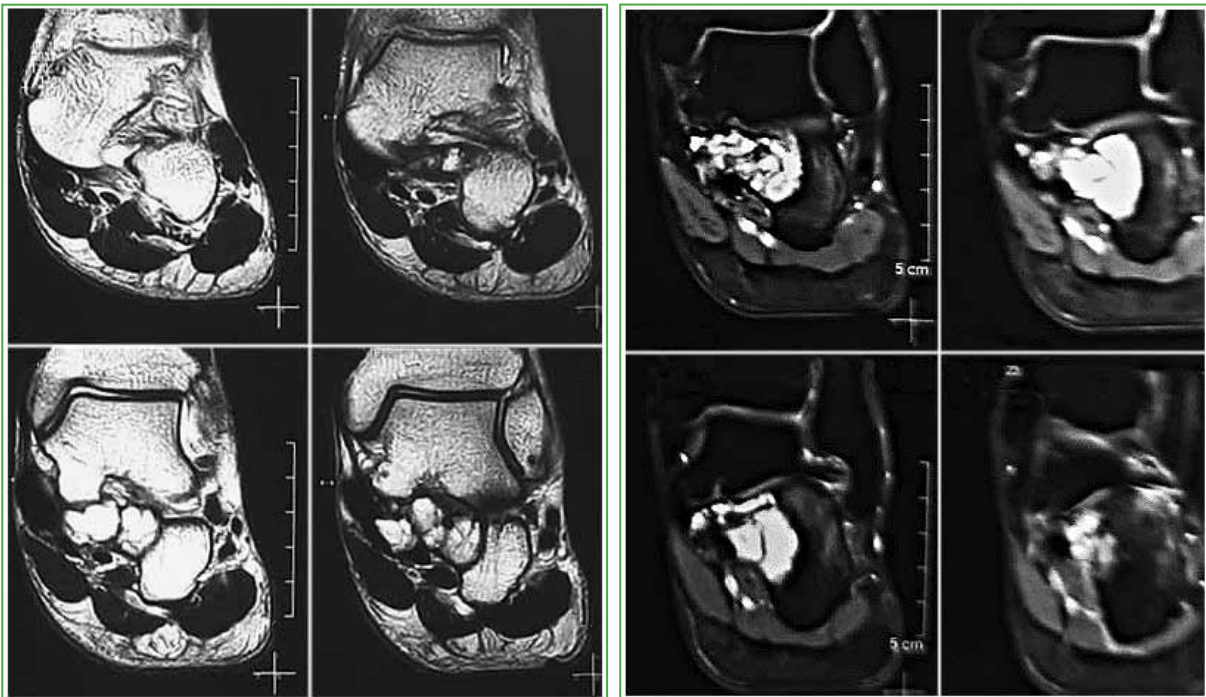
Coronal non-contrast MRI of the left foot. A multilobulated, polycystic lesion with fluid-fluid levels is seen, confined within the cortices of the left calcaneus.
